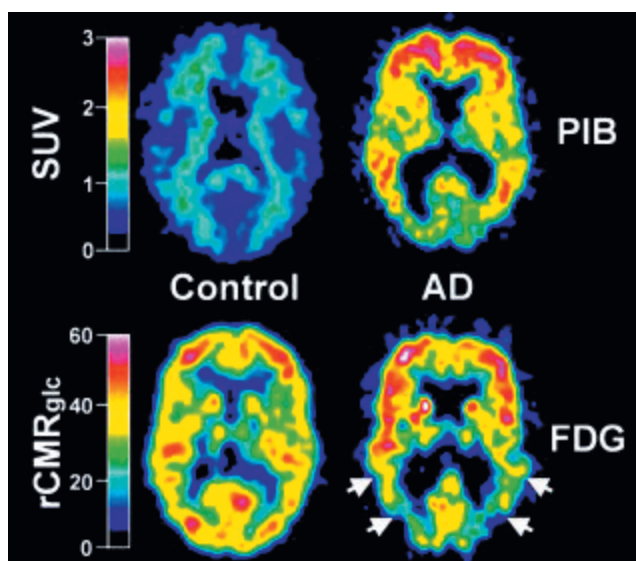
^{11}C -PiB standardized uptake value (SUV) and ^{18}F -FDG $r\text{CMR}_{\text{glc}}$ images in AD patients and healthy control (HC) subjects¹³. Reproduced by permission of John Wiley and Sons.
